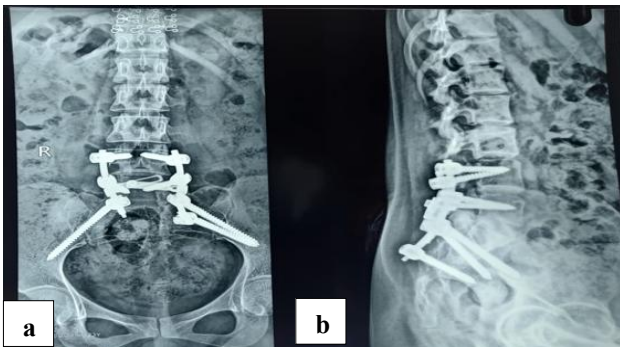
(a and b): Postoperative anteroposterior and lateral radiographs of the pelvis and lumbosacral spine showing stable lumbosacralpelvic fixation.
